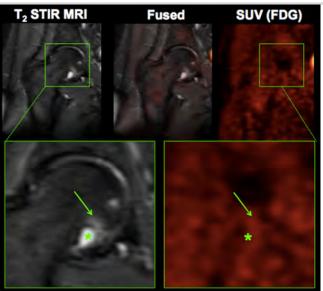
[18F]-FDG PET images in the hip of a 64-year old patient, co-registered and fused with T2-weighted STIR MRI. Cyst identified on the MRI (asterisk) has higher mean SUV of 1.9 ± 0.3 relative to the adjacent area of edema (arrow) with SUV of 1.4 ± 0.3 .
